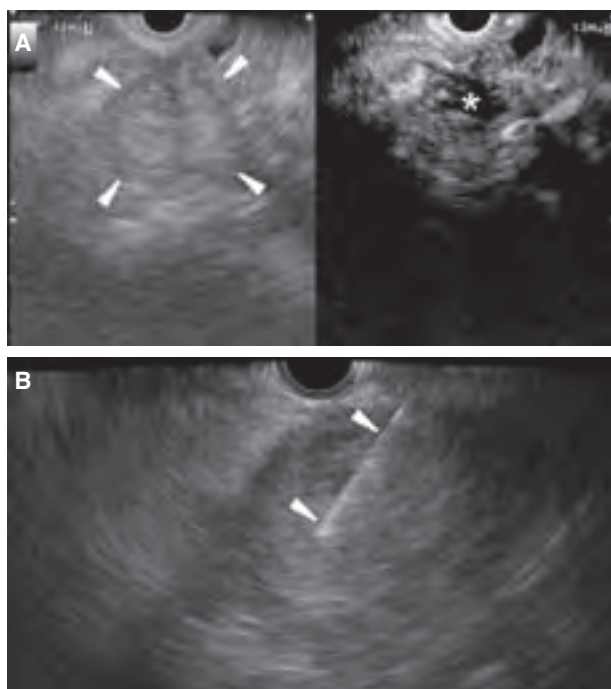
Contrast-enhanced harmonic endoscopic ultrasound (CH-EUS) images of pancreatic carcinoma with a necrotic area. (a) Conventional EUS (left) shows a tumor of 35 mm in diameter (arrowheads) at the pancreas head. CH-EUS (right) identifies an avascular site (asterisk) at the center of the tumor. (b) EUS-fine-needle aspiration is carried out at the periphery of the tumor. Arrowheads indicate a needle.
